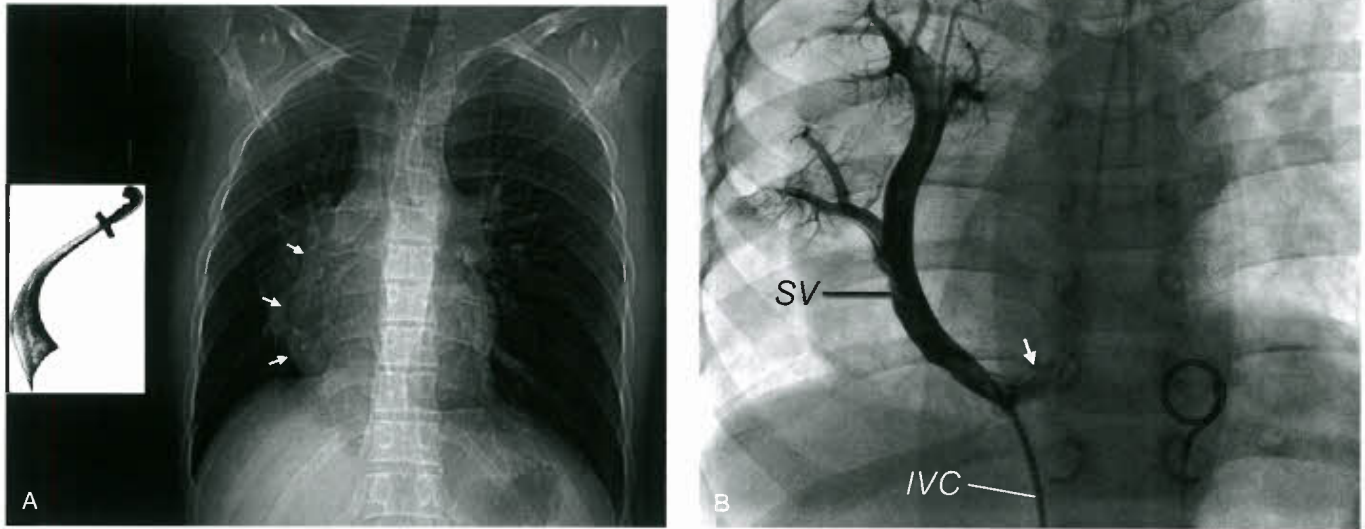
Scimitar syndrome. A: Chest radiogram in the posteroanterior projection showing the scimitar sign (arrowheads). Note the rightward shift of the cardiac silhouette. The inset shows a Turkish sword called scimitar. B: Catheter angiogram with catheter advanced from IVC up the SV in the same patient. Note the connection with the IVC close to the right atrial junction (arrow). C: 3-D lung surface volume rendering derived from computed tomography imaging in the same patient as (A). Note the degree of right lung hypoplasia.
